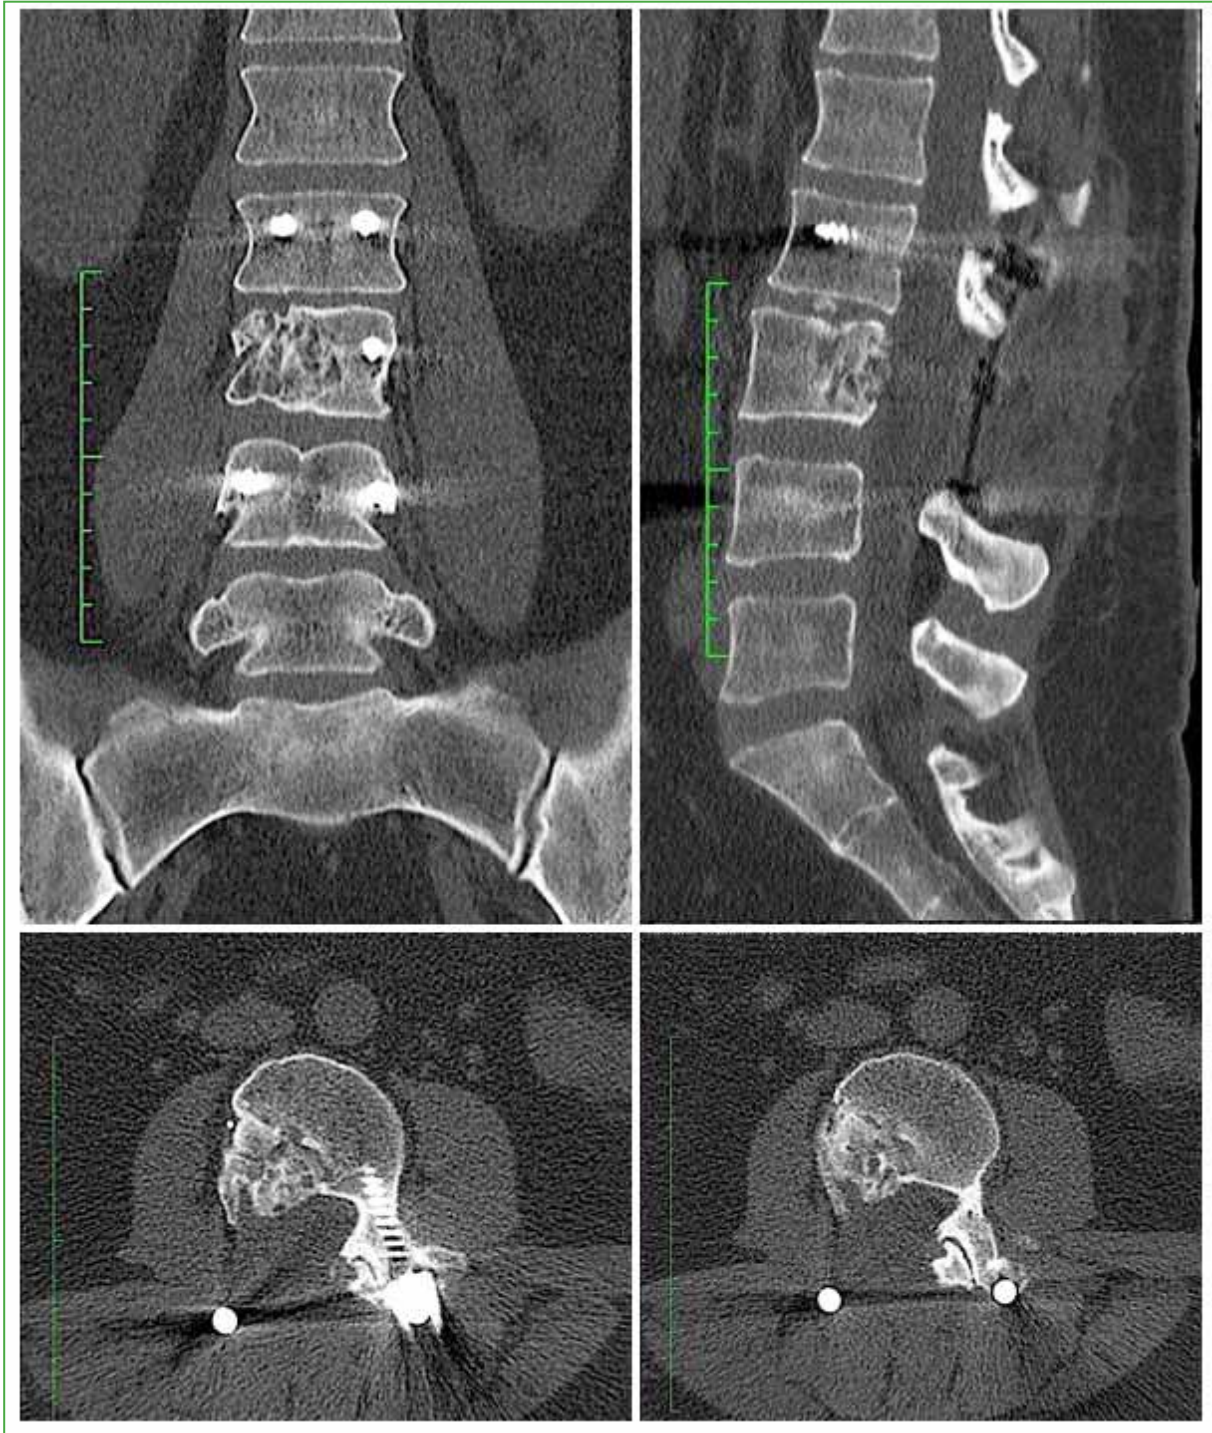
Control computed tomography after one year of treatment with denosumab.
